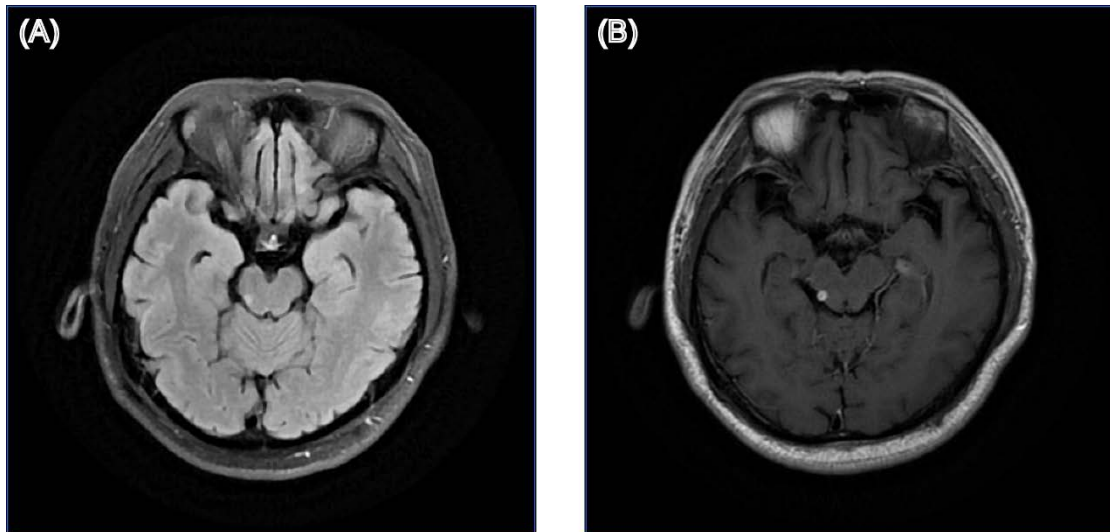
Structural brain MRI images of patient 12. (A) T2-weighted fluid-attenuated inversion recovery (T2-FLAIR) image; (B) Gadolinium-enhanced T1-weighted (Gd-T1w) image.
